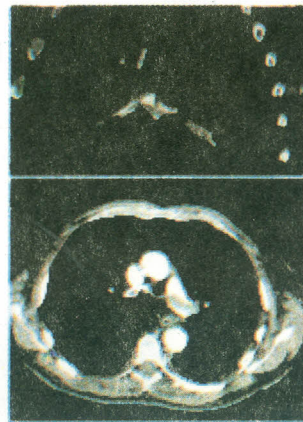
Pulmonary CT scan
